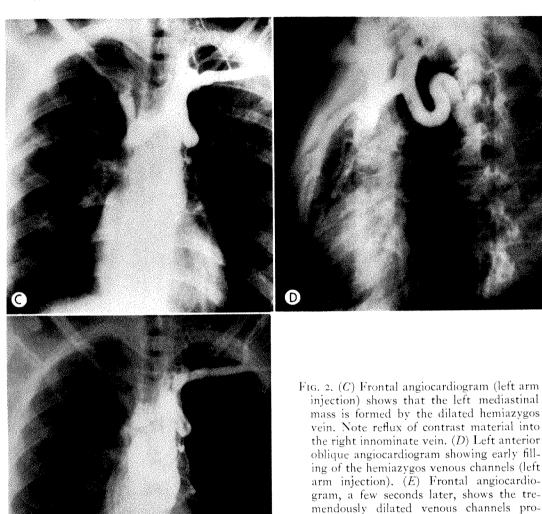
Case II. (A) Frontal teleroentgenogram showing a small left mediastinal mass (arrow). (B) Lordotic frontal roentgenogram again showing the mass (arrow).
